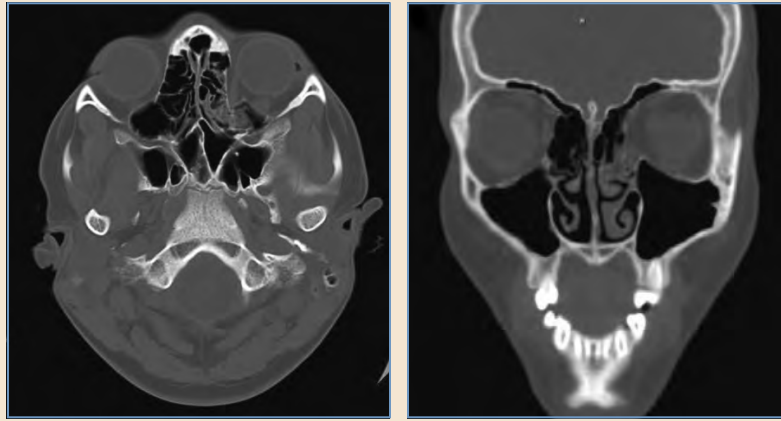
Axial and coronal CT slices of the facial bones show an entrapped medial orbital wall fracture. This 12-year-old male was kicked in the face during a martial arts class. He presented with slight restriction of superolateral gaze of his left eye with associated severe pain and diplopia. Mild bradycardia occurred with extreme lateral gaze. The patient underwent an exploration of the medial wall fracture through a transconjunctival incision. The medial rectus and orbital contents were reduced, and a resorbable plate was placed to repair the medial orbital wall.
